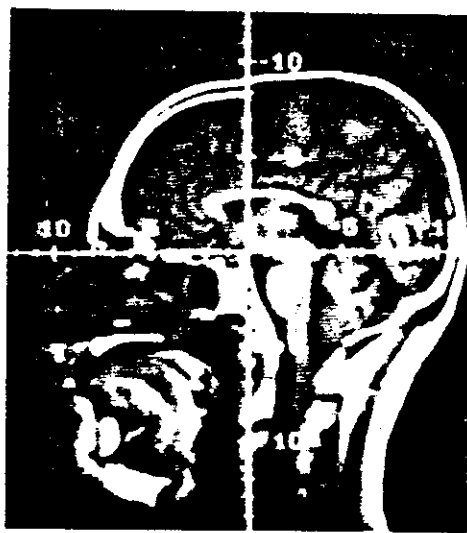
a) An MRI juxtaposed with b), a figure taken from Gray's Anatomy.¹⁸ Note that the white and grey matter in the brain is clearly distinguished, as are the corpus callosum, the cerebellum, the medulla, and sinus passages.
